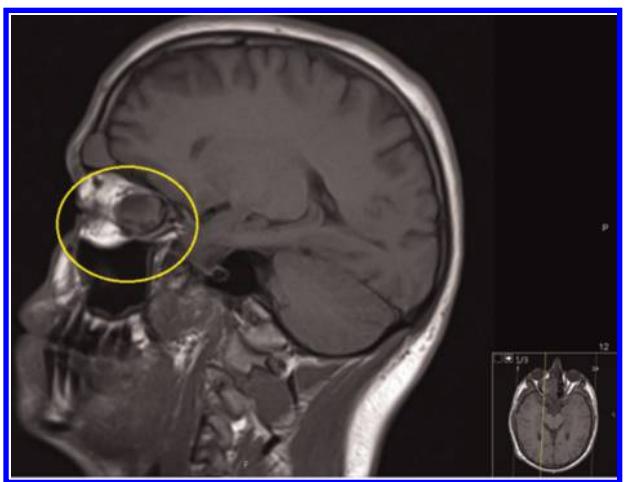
Preoperative sagittal magnetic resonance images.
